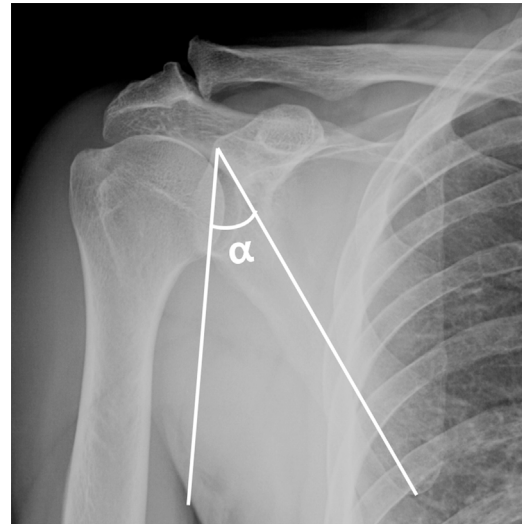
Measurement of glenoid inclination on scapula anteroposterior radiography. The angle (α) between the line from the most superior to inferior points of the glenoid and the most superior point of the glenoid to the line from the most inferior point of the scapula are depicted.
